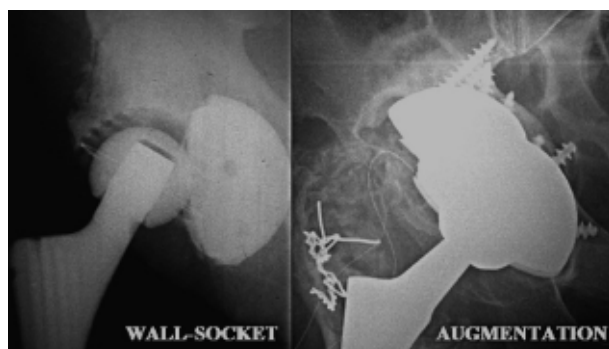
X-rays of a patient treated with the “Wall-Socket” technique (on the left) and of a patient treated with an Artificial Trabecular Metal Acetabular Augment (on the right). The “Wall-Socket” technique could be interpreted as an “Inverted Augment” located in DeLee and Charnley’s zone 3. Instead of an Acetabular Augment, the forces that primary prosthetic socket of the “Wall-Socket” is subjected to, are tensile instead of compressive ones
